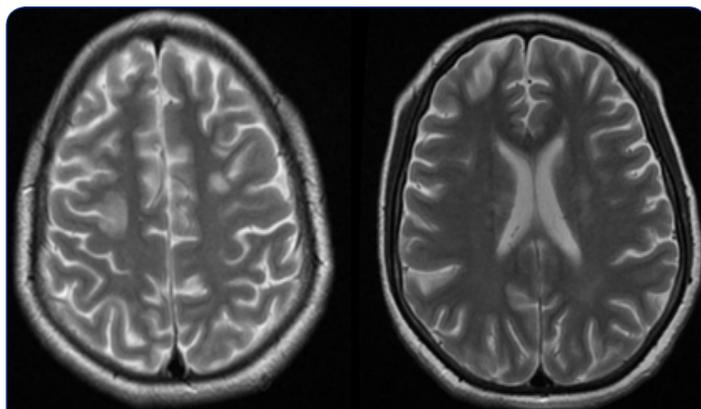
MRI classified as grade 1 (mild vasogenic edema)
